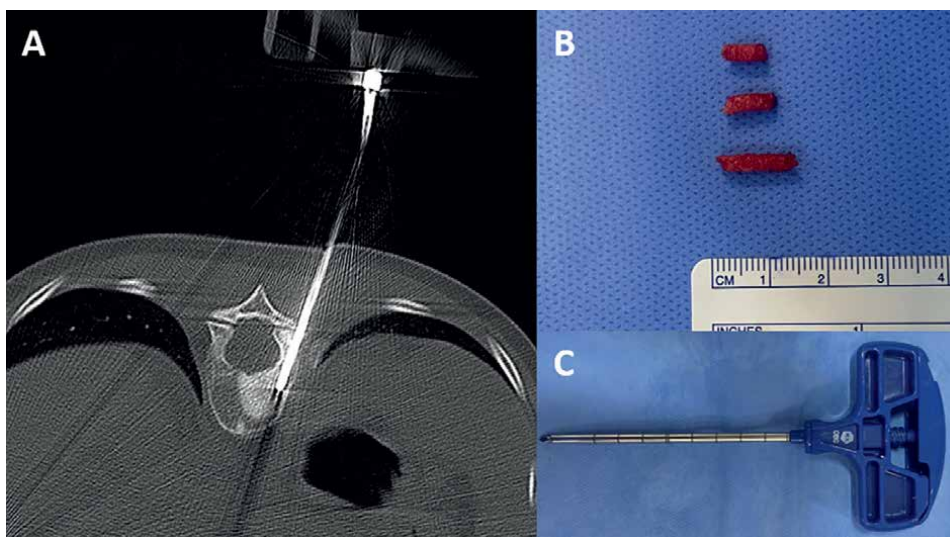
(A) biopsy of osteoblastic lesion in vertebral body guided by CT scan, (B) bone fragments removed with a core needle, and (C) core needle.
